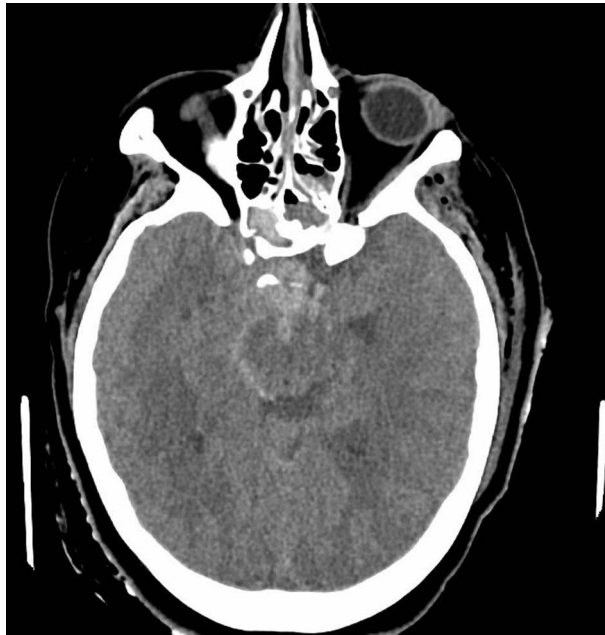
Axial view of the CT showing subarachnoid hemorrhage.
